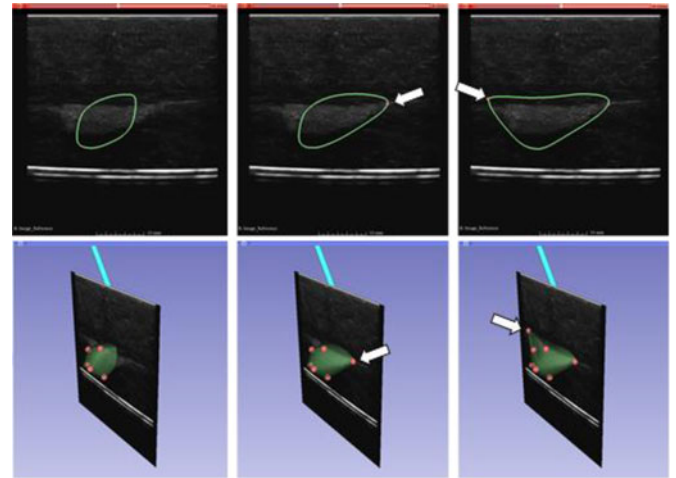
Tumor margins are represented by a 3-D surface (green) including tumor margin points (red) picked by the user. As new points are added on the 2-D ultrasound images (top row), the 3-D margin model (bottom row) is updated automatically. Light blue stick represents the localization needle. White arrows point to new tumor margin points defined by the user.
